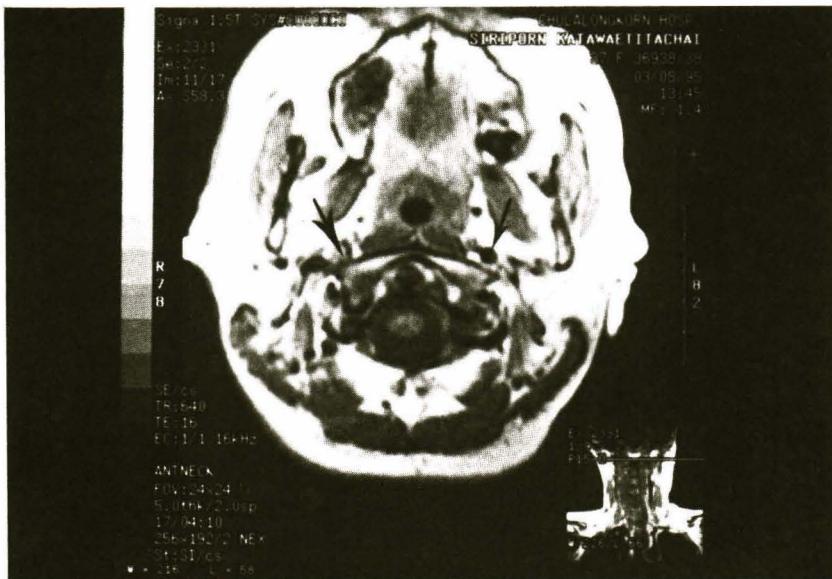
MRI at the site of dissection revealed the partially occluded right internal carotid artery with the high signal intensity in T₁W₁ which indicated a clot in the dissected arterial wall and a narrowed signal voided lumen which represented partial compressed vascular lumen (large arrow). Normal left internal carotid artery (small arrow).
